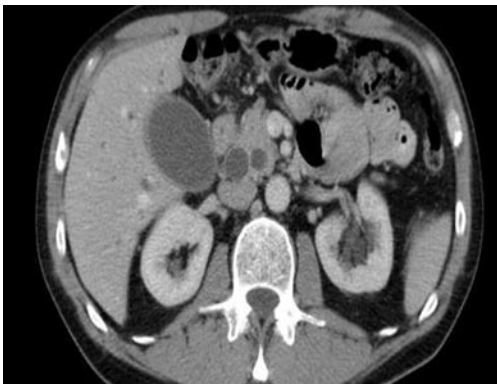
The characteristic “double duct sign” on abdominal CT is indicative of obstruction at the level of the ampulla.
